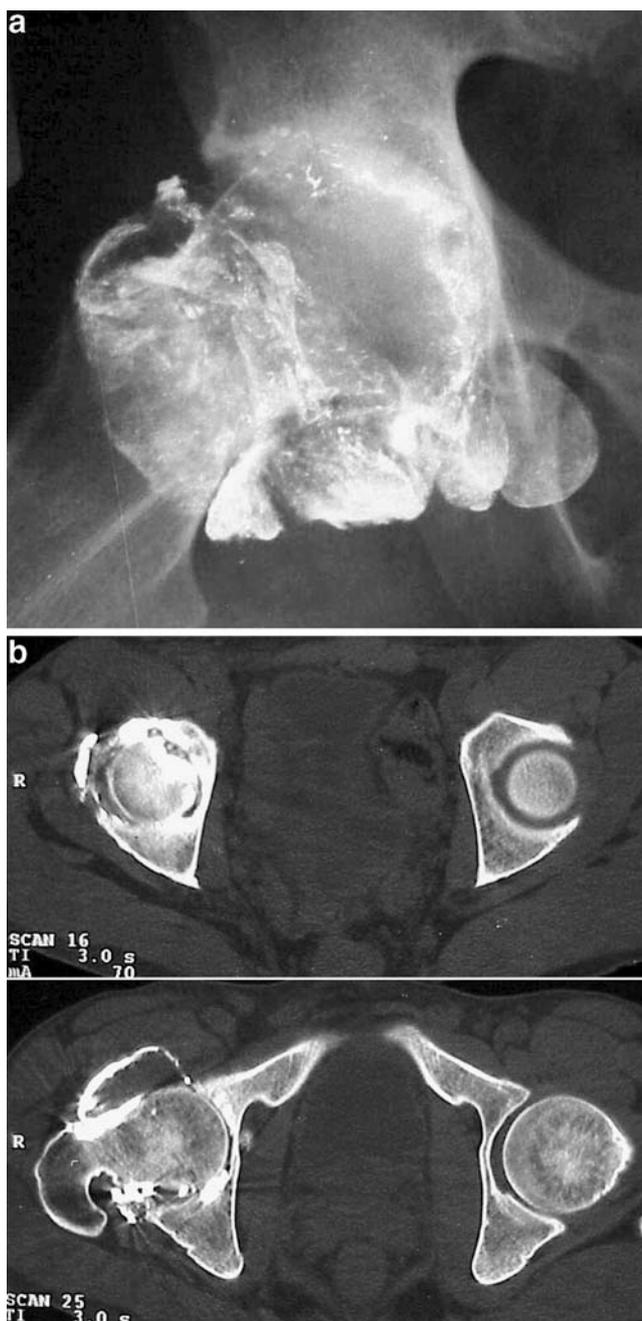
Lead arthropathy of the right hip (case 3). a Plain anteroposterior radiograph showing that the joint space is asymmetrically reduced and the joint capsule is entirely outlined by metallic particles, configuring a lead arthrogram. b CT scans, besides confirming the radiographic findings, reveal joint effusion and a thick stripe of lead embedded in the synovium of the right hip. The bullet is no longer visible
